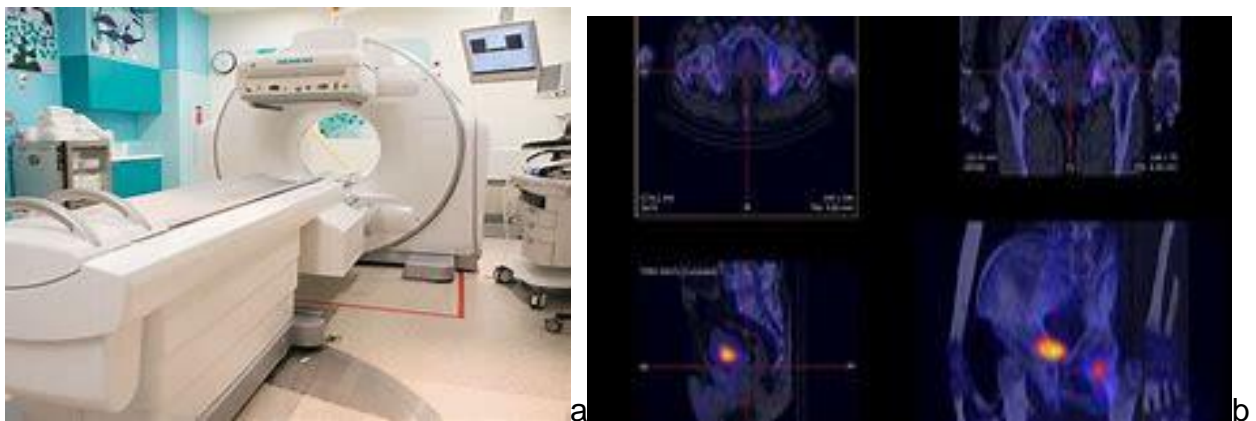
a) SPECT-CT scanner b) Image taken with a SPECT-CT system.
